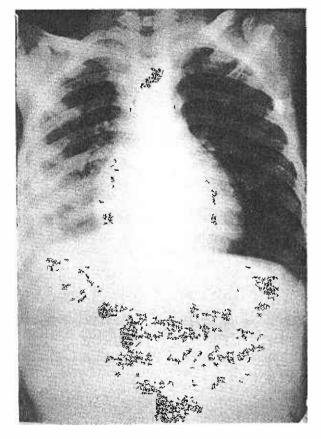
Radiograph of the chest to show clearing of the opacity due to a pleural effusion with antituberculous drugs and steroids over a period of ten days.
